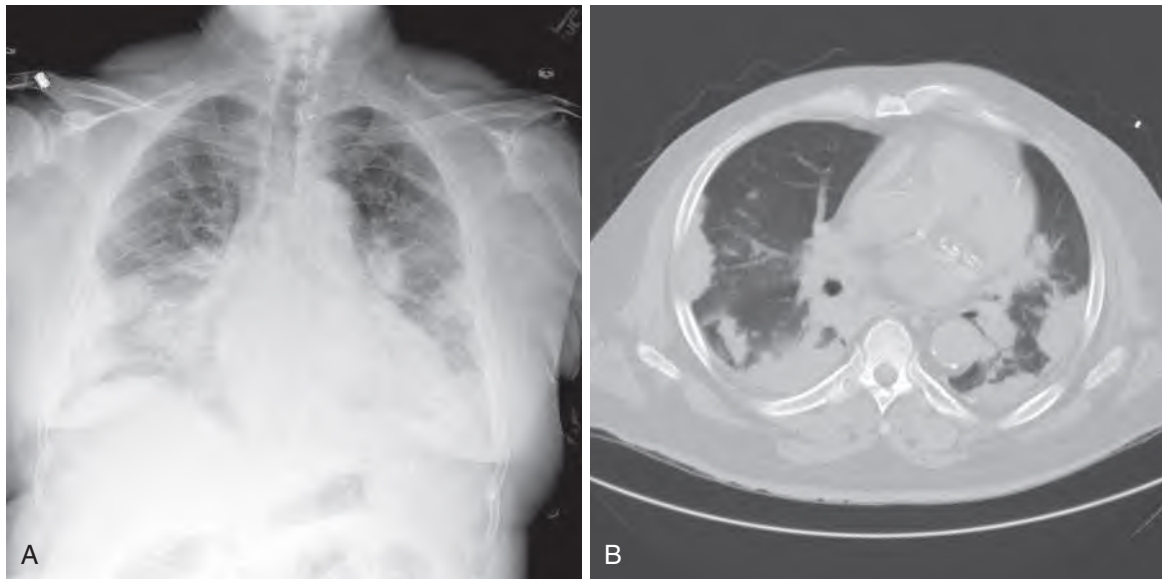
(A) This 71-year-old black male with history of a renal transplant approximately 5 years ago presents with fever, cough, exertional dyspnea, and mild headache over the past 4 weeks. He is stable on his current immunosuppressant regimen. He works as a dairy farmer. Bronchoalveolar lavage and blood cultures at baseline were positive for *Cryptococcus neoformans*. Note the bilateral diffuse nodular lesions. Cerebrospinal fluid cultures and cryptococcal antigen assay were negative. (B) A computed tomography scan from the patient reveals multiple, bilateral parenchymal and pleural-based, noncavitary pulmonary nodules, consistent with a diagnosis of extensive pulmonary cryptococcosis.
